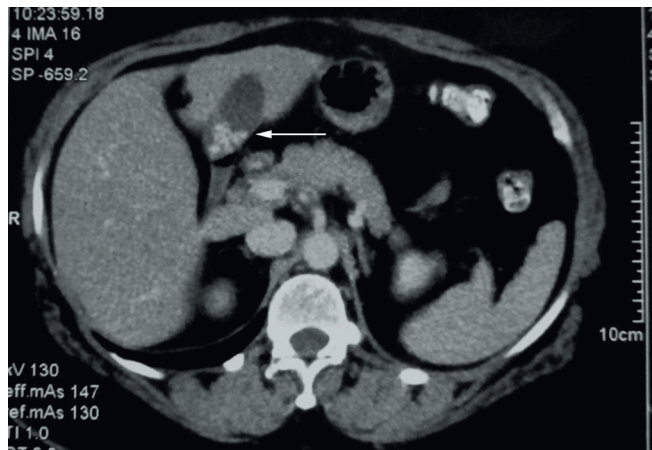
CT scan showing gallstones (arrow) in a left-sided gallbladder.
